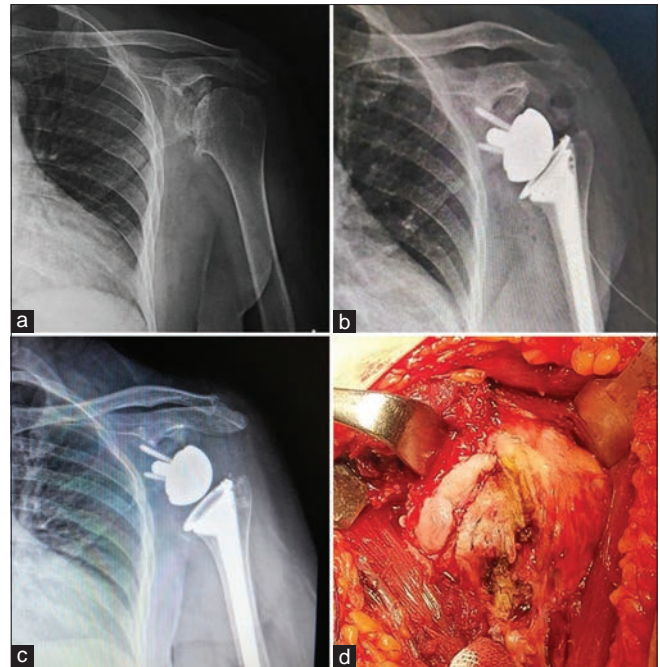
(a) Preoperative plain X-rays of patient with glenohumeral osteoarthritis, (b) Post-operative plain X-rays, (c) last follow-up plain X-rays, (d) Showing osteophytes around the head of humerus
